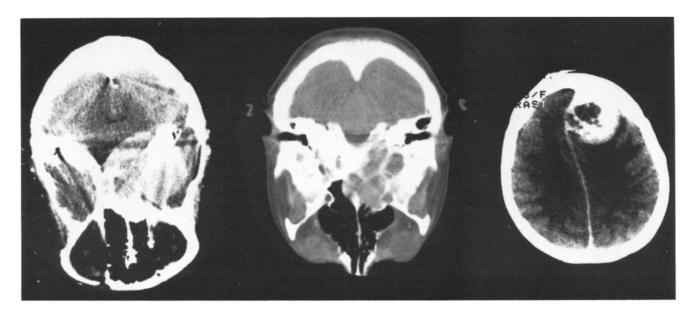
Three CT pictures showing "malignant" tumour behavior (left and middle), or necrosis and cyst formation (right). On the left the suprasellar tentorium meningioma of patient 20 is shown: there is inhomogeneous contrast enhancement and irregular circumscription of the tumour. The same tumour is shown at a higher level in the middle panel. Extensive bone destruction of the apex of the os petrosum, as well as of the pituitary fossa is seen. The CT of the parasagittal falx meningioma of patient 24 is shown on the right. There is inhomogeneous enhancement of contrast, as well as evidence of cyst formation and/or necrosis.
